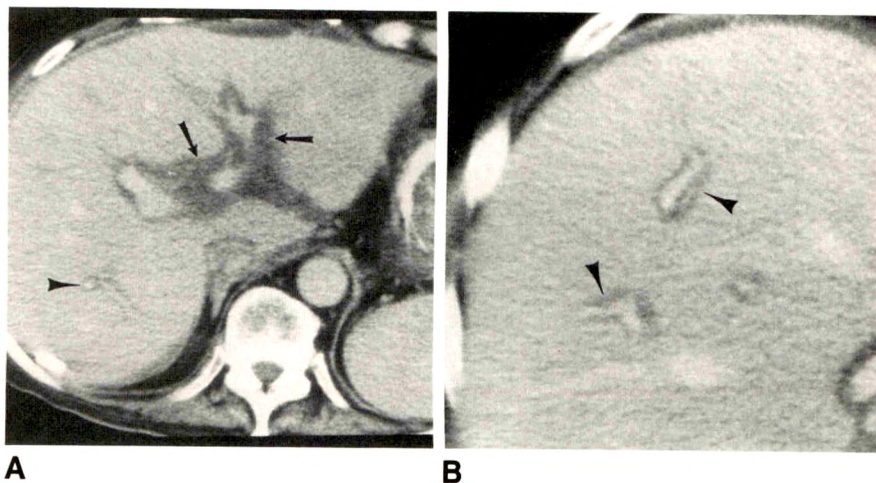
Low-attenuation periportal collar on CT scans of 61-year-old man, 3 weeks after hepatic transplantation.
